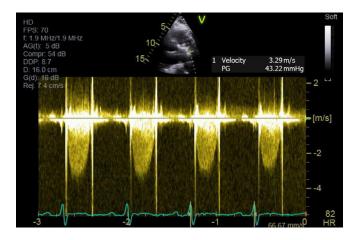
Continuous wave Doppler interrogation of the pulmonic valve. Spectral Doppler depicting significant pulmonic valve regurgitation and severe stenosis.
